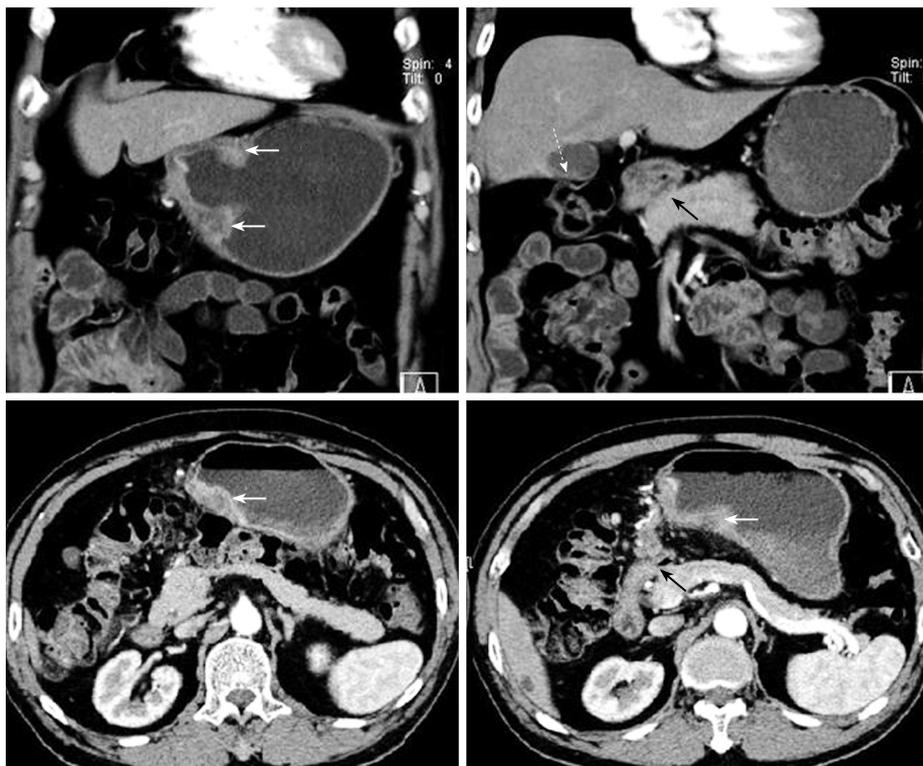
Preoperative abdominal CT images in coronary and transverse sections. The white solid arrows indicate diffuse wall thickening at the gastric antrum. The white dotted arrow indicates a contracted gallbladder with eccentric wall thickening. The black solid arrows point to the apparent deformity of the duodenal bulb with adhesion to the head of the pancreas. There is no evidence of intra-abdominal metastasis in this study.
